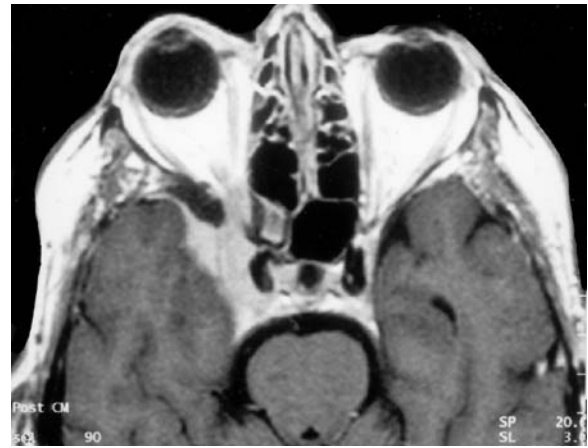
A 51-year-old woman with progressive visual deficit of the left eye. Diagnosis: left sphenoid (small) wing meningioma. T1-weighted, contrast-enhanced HR-MRI: the tumor progresses from the distal area of the clinoid process (arrow) to the optic canal. Note the anterior dislocation of the prechiasmatal part of the flattened, attenuated optic nerve (small arrows) to the lateral posterior wall of the sphenoid sinus, and the flattened, impressed, dorsal dislocation of the (hyperintense) ICA bifurcation area with proximal MCA (white star: chiasm). (From MÜLLER-FORELL and LIEB 1995)
